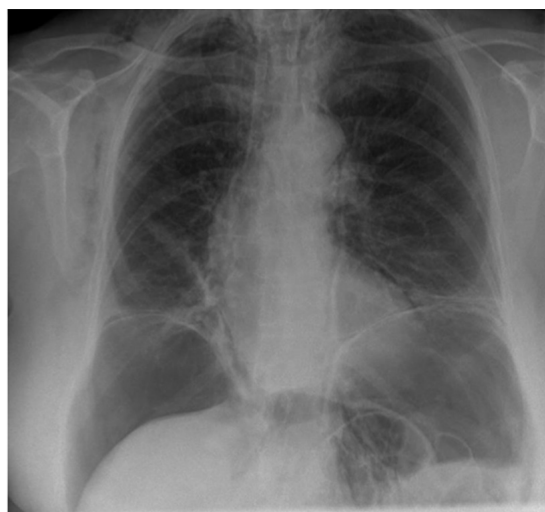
Chest X-ray with massive pneumoperitoneum
